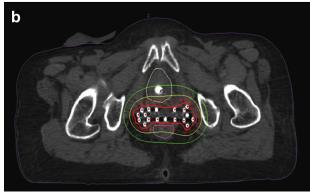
CT scan—based brachytherapy planning on Plato system. (a) The contouring of bladder (brown), rectum (pink), and target area (red). Target area is delineated by joining the peripheral implant needles. (b) The isodose distribution showing the prescription line (thin red line) and 60% isodose line (green line) (please refer the online version of the figure for colors).
